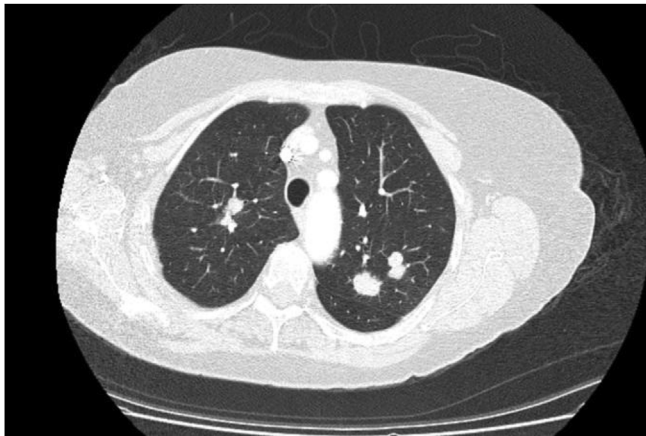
CT image showing well circumscribed bilateral pulmonary nodules.
